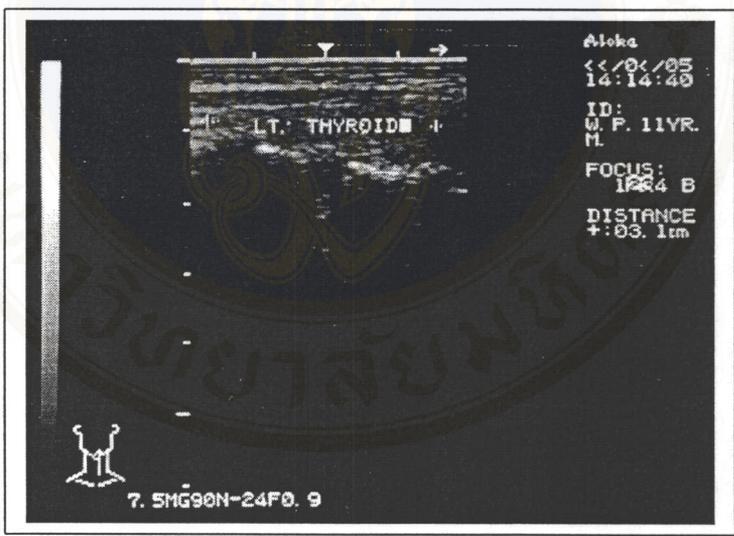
Ultrasonography : parasagittal section of thyroid ultrasonography.
